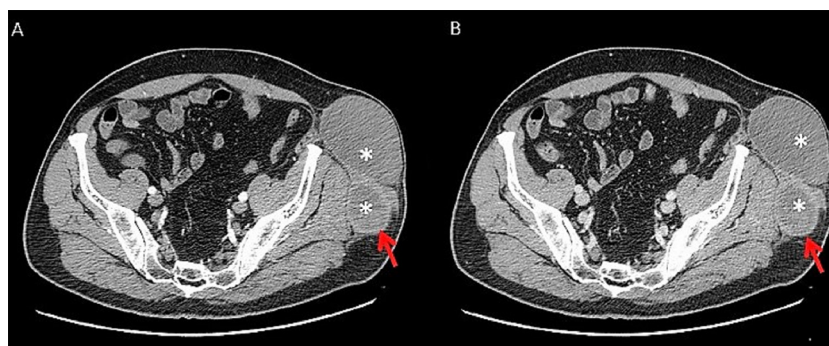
Axial contrast-enhanced CT of the abdomen and pelvis (arterial and portal phase). Technique: rotation time, 0.8 second; 300 mAs; 120 kV; 2.5-mm slice thickness; contrast medium: 120 mL of Iomeron 350 (Bracco, Italy). Scan delays: arterial phase: 35 seconds; portal phase: 80 seconds. The lesion is located between the internal abdominal muscle and the subcutaneous tissue of the abdominal wall, extending up to the level of the gluteus medius muscle. Fluid-fluid levels (asterisks) can be appreciated. Contrast enhancement of the peripheral capsule can be appreciated (arrows). No hemorrhagic foci are evident.
